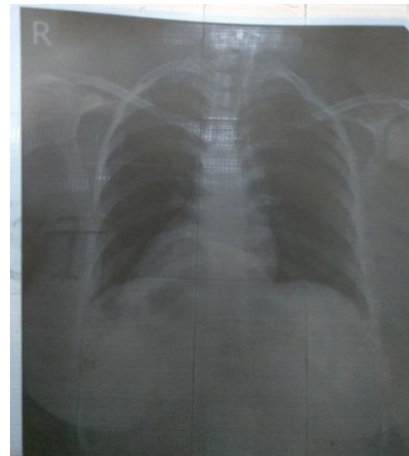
Chest X-ray PA view shows dextrocardia, right sided fundal gas shadow with R/L superimposed breast shadow.
